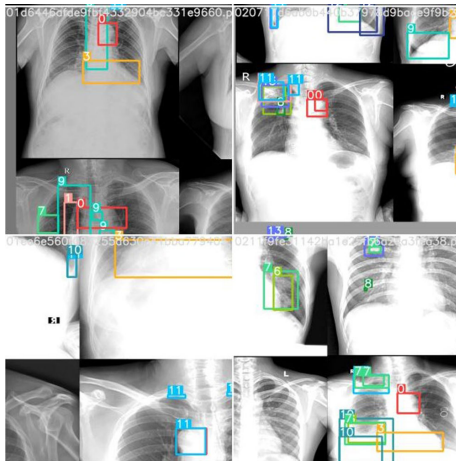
An example of chest x-ray images was applied mosaic technique.
